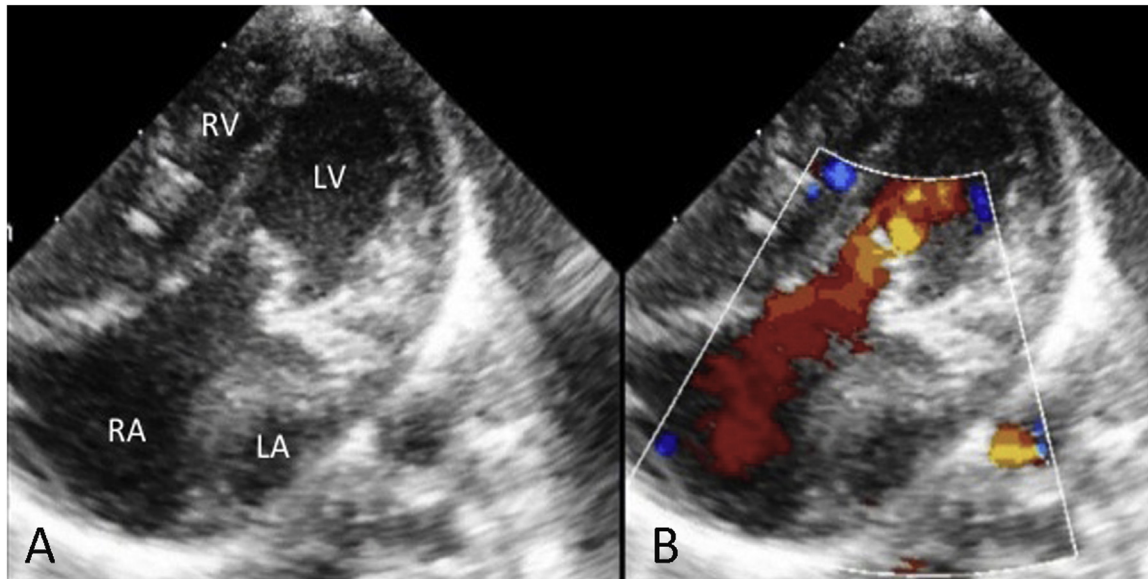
A. Two-dimensional and B. color Doppler transthoracic echocardiographic images obtained in apical four-chamber view showing twisted and discordant atrio-ventricular connections with the right atrium (RA) draining into the contra-laterally located morphological left ventricle (LV).
